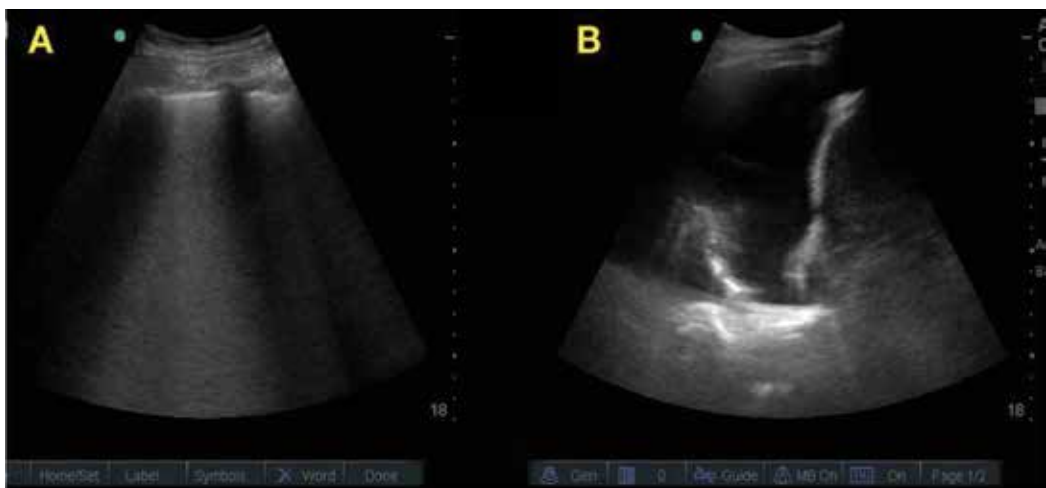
Case of acute cardiogenic pulmonary edema. Evident by B lines (A), which are the vertical narrow-based lines arising from the pleural line to the edge of the ultrasound screen, which was present in both hemithoraces, and bilateral pleural effusion (B). In addition, cardiac ultrasound showed decreased left ventricular systolic function (not included in the figure) which supports the diagnosis of acute cardiogenic pulmonary edema.
